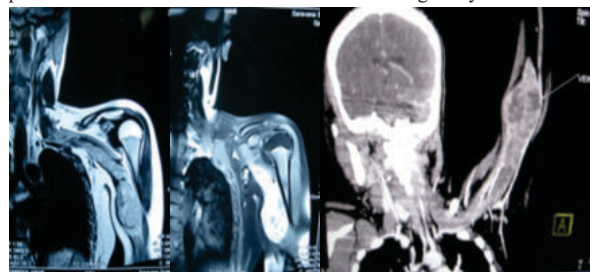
MRI Picture Showing The Lesion Involving The Left Brachial Plexus
